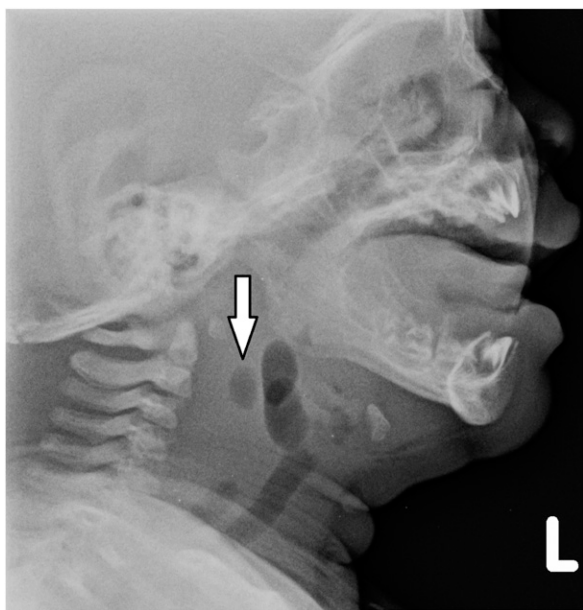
Lateral neck radiograph highlighting radiolucency in retropharyngeal space (arrow) concerning for free air.
